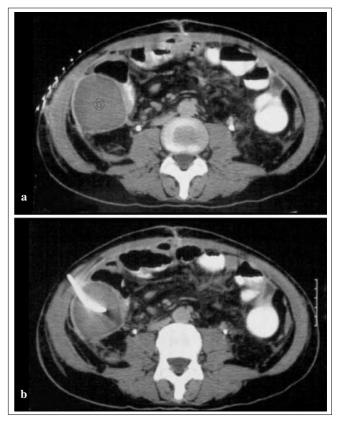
Axial CT images of a fluid collection in the right abdomen. In this case, the optimal access route for PAD is lateral trans-abdominal since the anterior abdominal approach is not recommended due to the interposed bowel loops. a Before treatment. b During treatment
